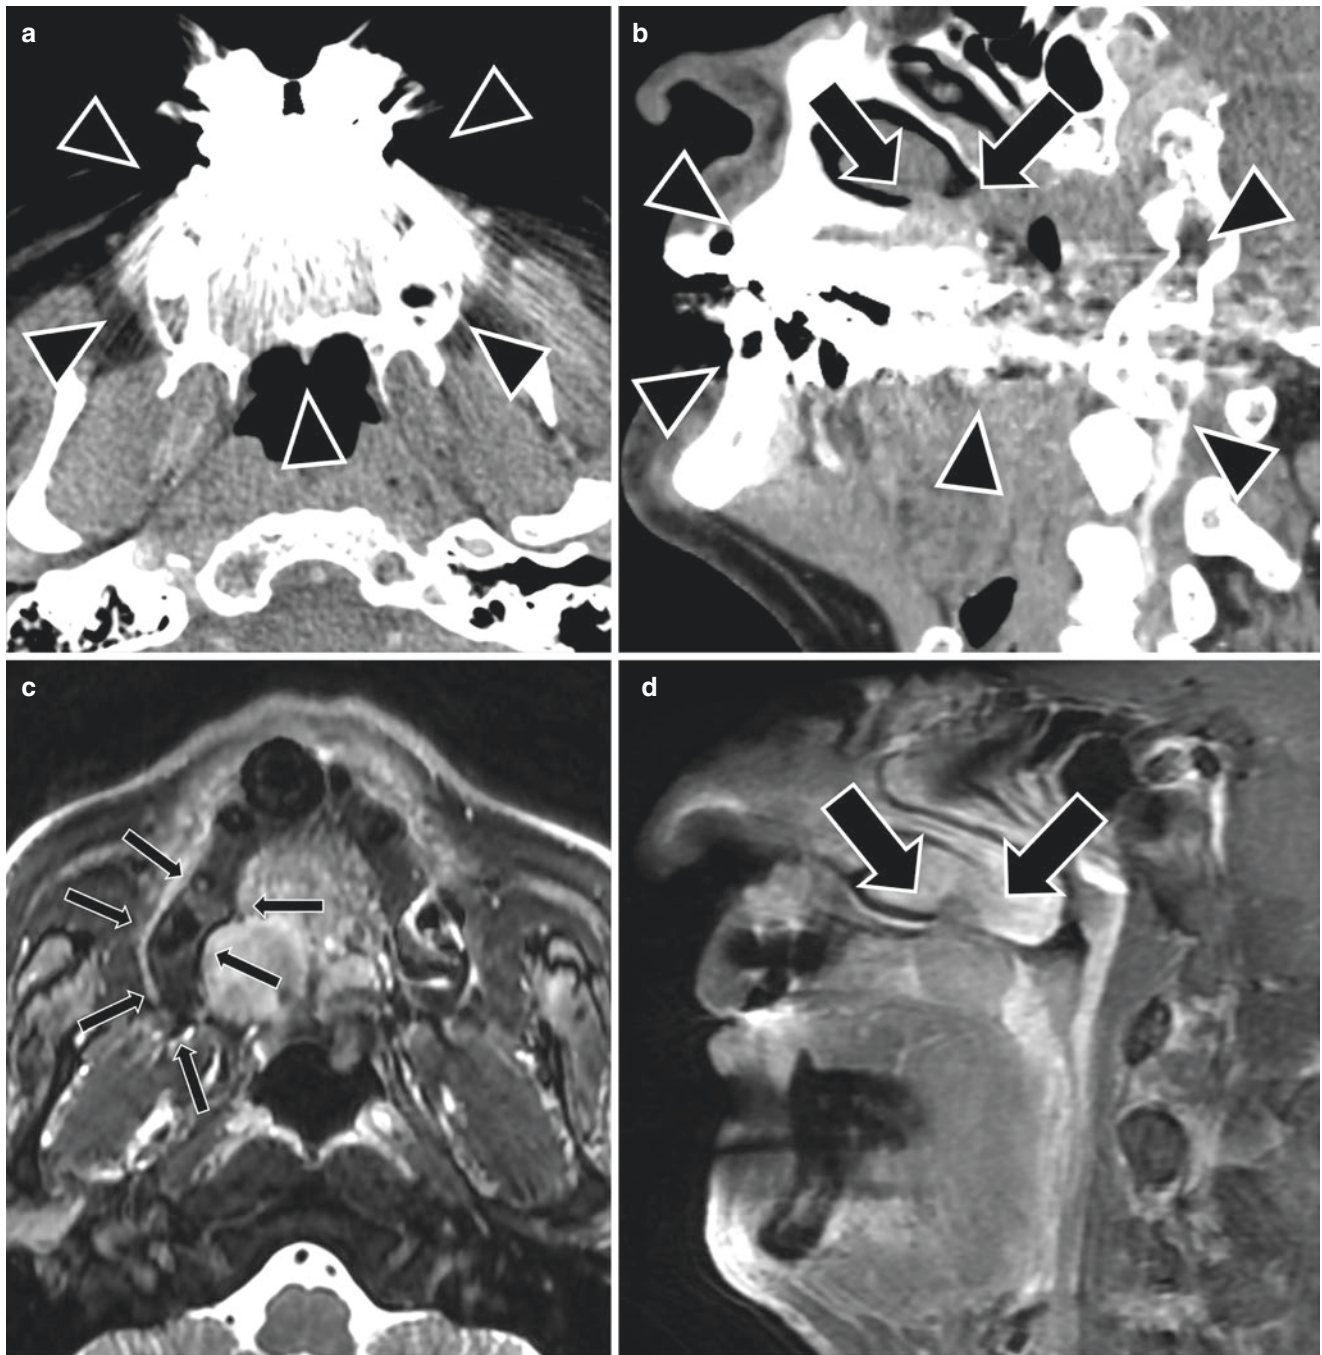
A 67-year-old man with mucoepidermoid carcinoma of the hard palate. The tumor infiltrated the nasal cavity and invaded the inferior nasal concha (b, d, f, and h, thick arrows), while the alveolar part of the mandible was spared (c, thin arrows). The margin of the tumor was hard to detect on CT (a, b) and PET/CT (e, f) because of artifacts from implants (a and b, arrowheads) and low soft-tissue contrast. In contrast, the margin was easily recognized on fat-sat T2WI and contrast-enhanced T1WI (c, d), and fused PET/MR images (g, h).
